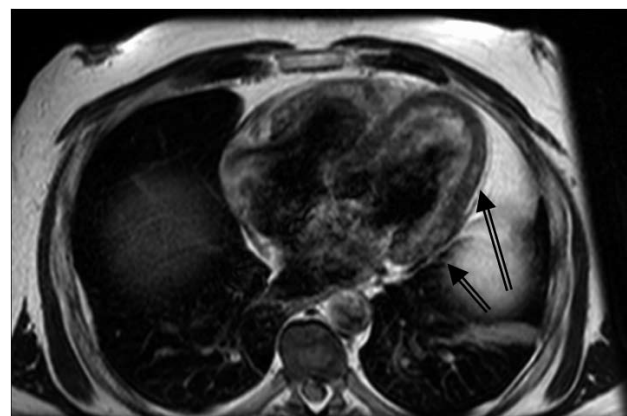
(a) T1-weighted black-blood transverse image. LA= left atrium, LV=left ventricle, RA=right atrium, RV=right ventricle
